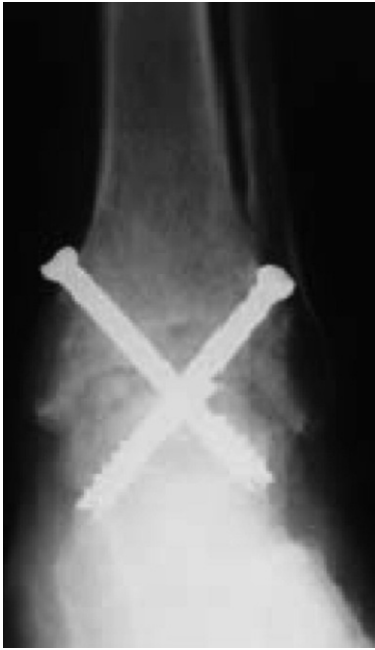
Anterior-posterior ankle weightbearing x-ray, 3 months post operative film.
